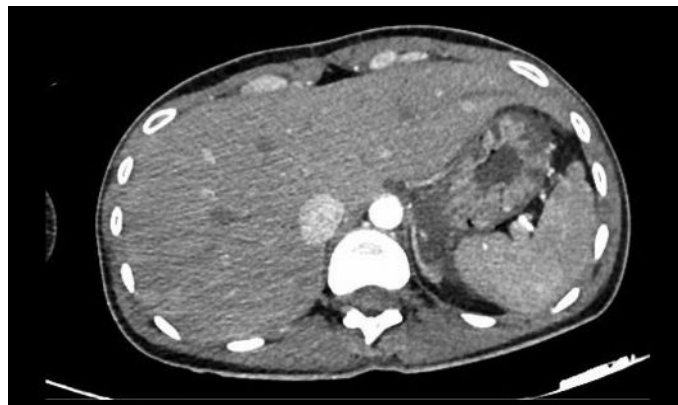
CT scan after the first HBO breath
